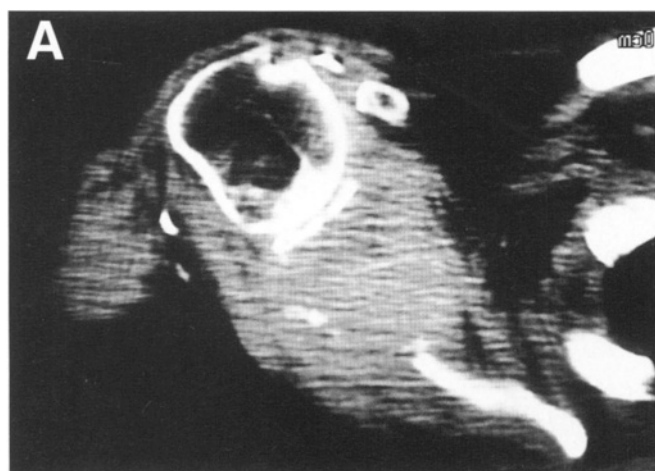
(A) Large Ewing's sarcoma of the scapula that involves the glenohumeral joint with a large extraosseous soft-tissue component. This patient was treated with induction chemotherapy followed by an extraarticular resection of the scapula and the humeral head (Type IV resection). This was reconstructed by a scapular prosthesis. A Gore-Tex graft was used to reconstruct the capsule and to restore stability. (B) Plain radiograph following reconstruction. The Gore-Tex is outlined in black and the Dacron sutures that attach the Gore-Tex graft to holes in the scapular prosthesis are marked by the small x.
